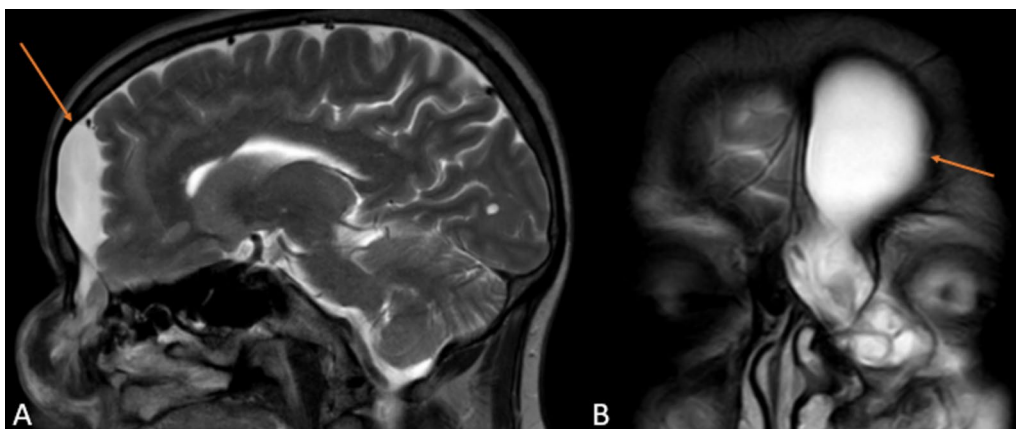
Sagittal T2WI MRI (A) and coronal T2WI MRI (B) brain shows herniation of the meninges, brain tissue, and CSF from the left frontal lobe extending anteriorly till the left lateral nasal bone with the formation of arachnoid cyst in the left frontal region
